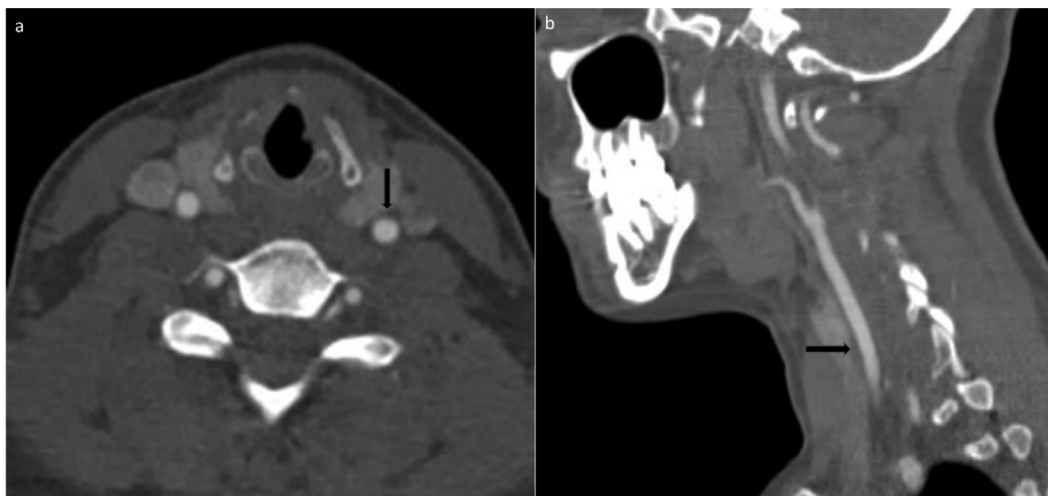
Two months after focal common carotid artery dissection, it has been showed that the amount of periarterial haematoma related to focal dissection was declined in axial (a) and sagittal (b) CT angiography images (arrows in a and b).
